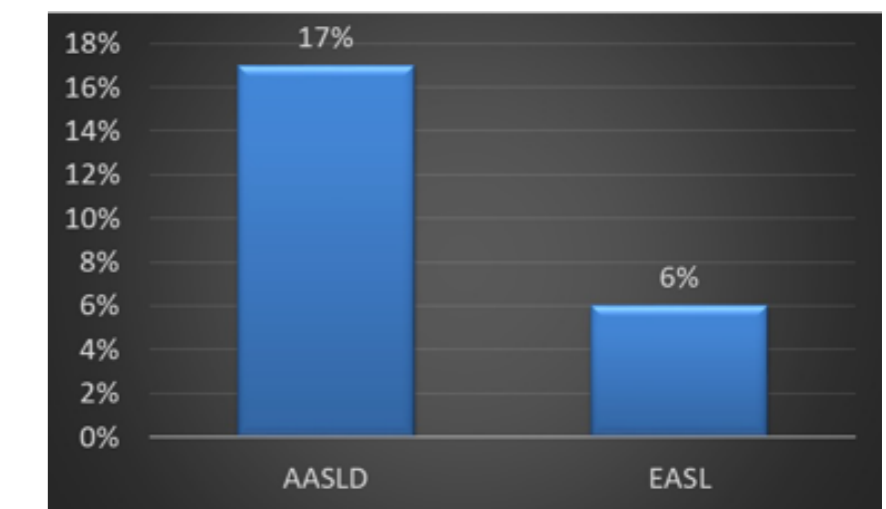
percentage of patients referred to ultrasound from patients identified as high risk as per AASLD and EASL guidelines
